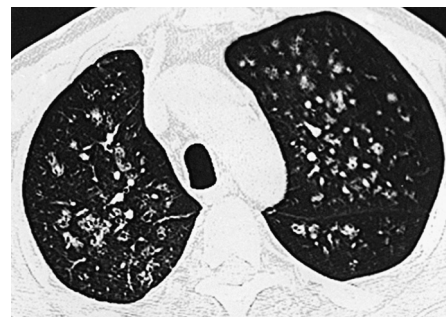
Metastatic calcification in the lungs secondary to chronic renal failure. A 59-year-old man with end-stage renal disease for 5 years complained of chronic progressive shortness of breath. The serum calcium level was 9.9 mg/dL (normal range, 8.5 to 10.5 mg/dL) and the parathyroid hormone level was 271 pg/mL (normal for the laboratory, 11 to 54 pg/mL). High-resolution computed tomography revealed numerous nodular ground-glass densities in a peribronchovascular pattern, most prominently in the upper lobes. (Courtesy Marcia McCowin, MD.)
